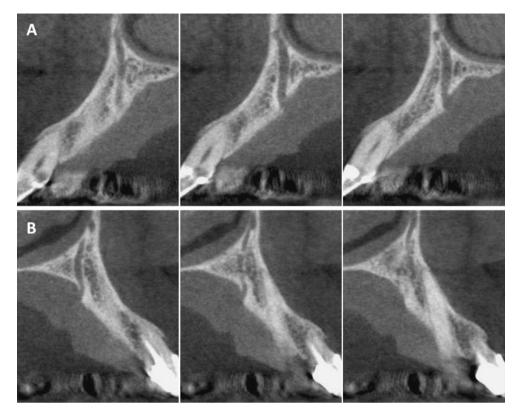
Sagittal CBCT slices showing the presence of the accessory canals on the right (a) and left (b) sides
